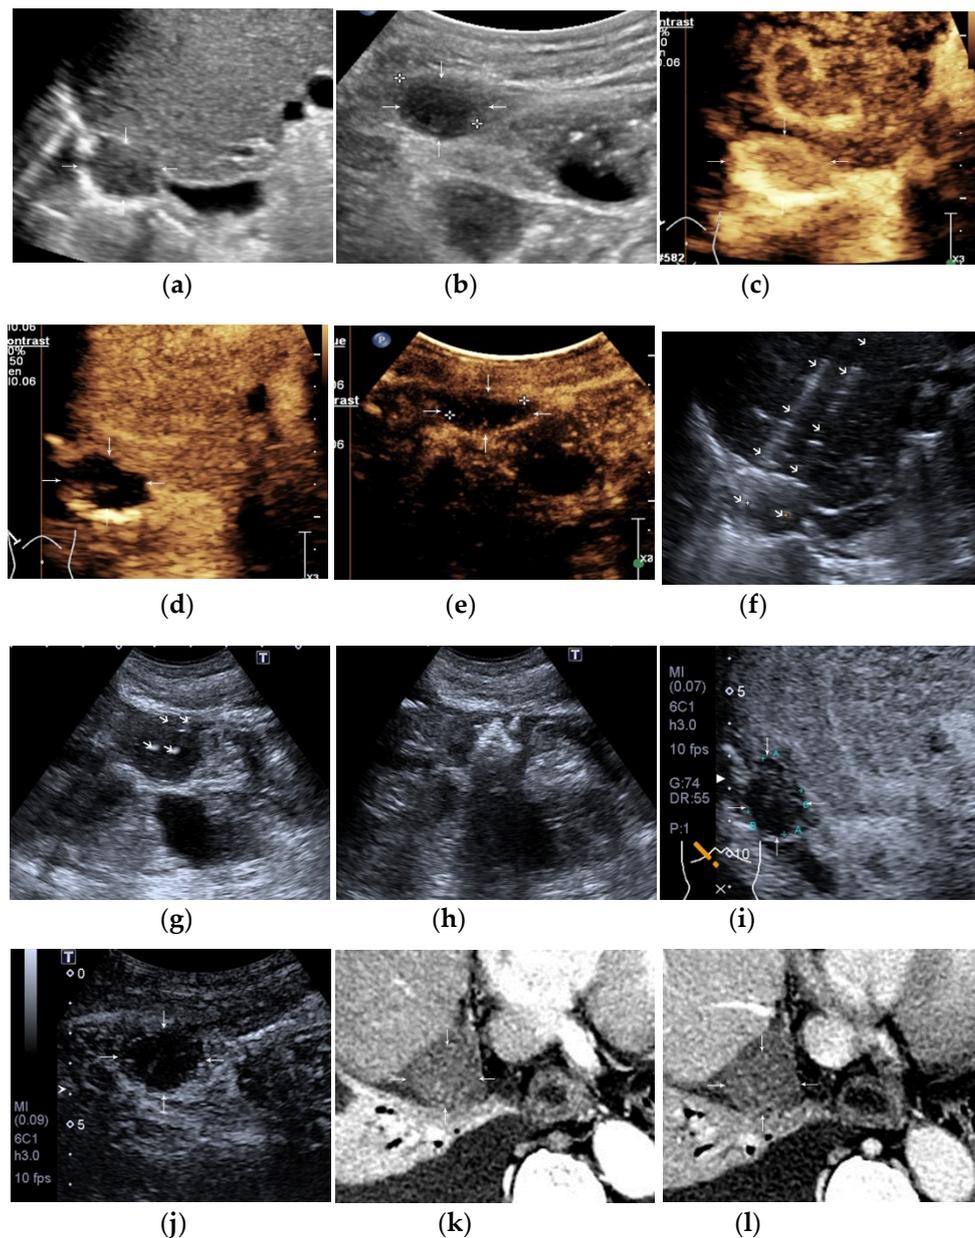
A 65-year old male had hepatocellular carcinoma (HCC) and was diagnosed with extrahepatic metastases to abdominal lymph nodes. US-guided laser ablation (LA) was performed. (a,b) A hypoechoic lymph node inferior to the right diaphragm (a) and right paracolon (b) were detected by the grayscale ultrasound. (c–e) On the contrast-enhanced ultrasound (CEUS) images, the targeted lymph node displayed heterogeneous hyperenhancement in the early phase (c) and washout in the late phase (d,e). (f,g) With the guidance of real-time US, optic fibers were inserted into the target lesions precisely and the tips of the fibers clearly seen. (h) Hyperechoic zone around the fiber tip appeared and the range extended as the procedure proceeded. (i,j) One month later, the target lymph nodes inferior to the right diaphragm (i) and right paracolon (j) showed no enhancement on the CEUS images, indicating a complete ablation. (k,l) One month later, target lymph node inferior to the right diaphragm exhibited no enhancement in the arterial phase (k) and in the portal-venous phase (l) on the contrast-enhanced computed tomography (CECT).
